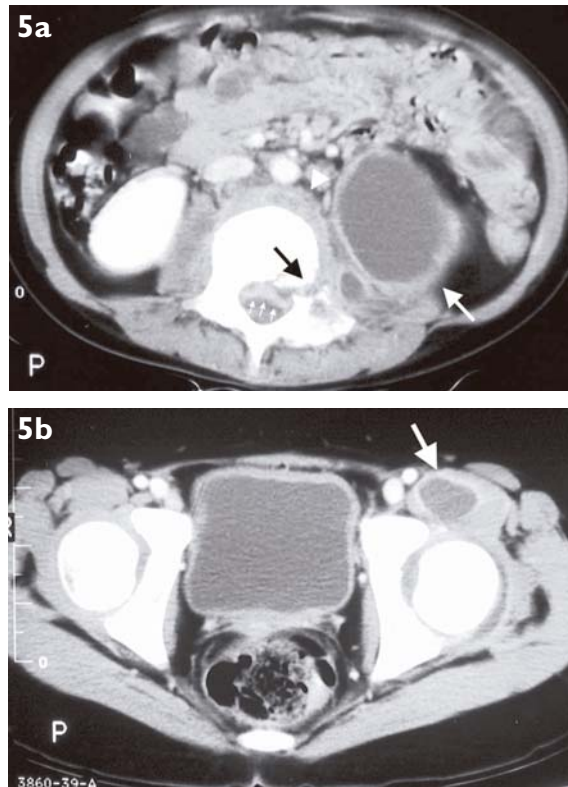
Spread of TB spondylitis through the left psoas muscle to the left groin in a 14-year-old boy. a) Enhanced axial CT image taken through L3 vertebral body shows bony destruction in the left pedicle (black arrow), large left psoas abscess (large white arrow), subligamentous spread (arrowhead) and extradural spinal canal invasion are seen (small white arrows). b) Axial CT image shows the psoas abscess tracking down into the left inguinal region (arrow).
